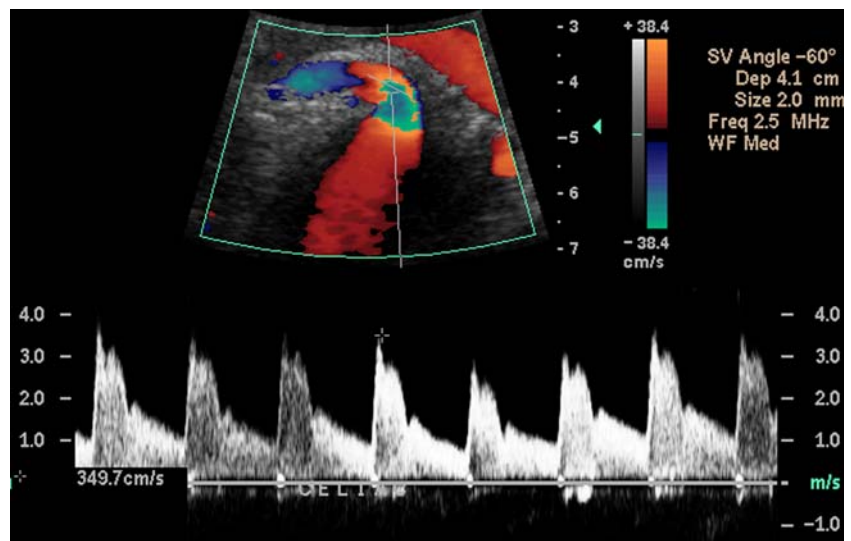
Color flow Doppler was used to identify the aorta, the celiac artery, and its branches.
